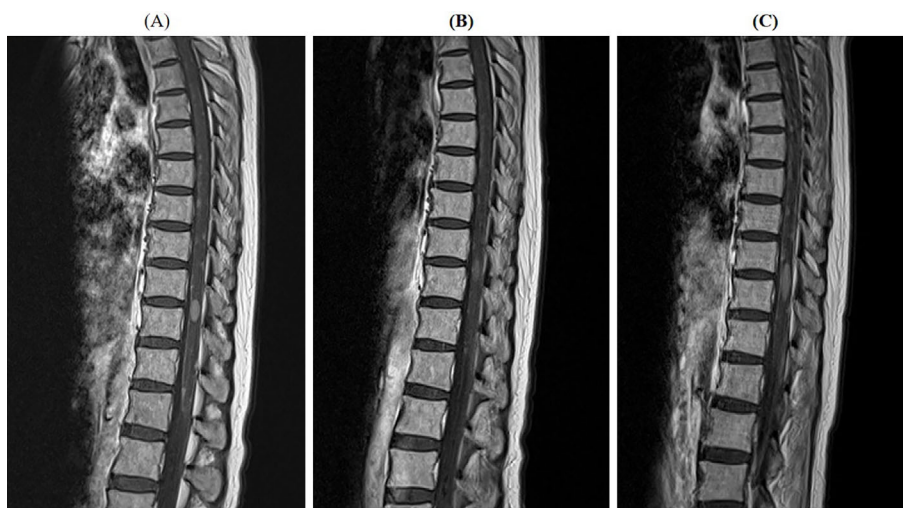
Spine magnetic resonance imaging showed multiple intramedullary metastases and meningeal dissemination before resuming ceritinib treatment (A). Three weeks after resuming ceritinib, the multiple intramedullary metastases and meningeal dissemination had markedly improved (B). However, after discontinuing ceritinib, the intramedullary metastases and meningeal dissemination worsened again (C).
